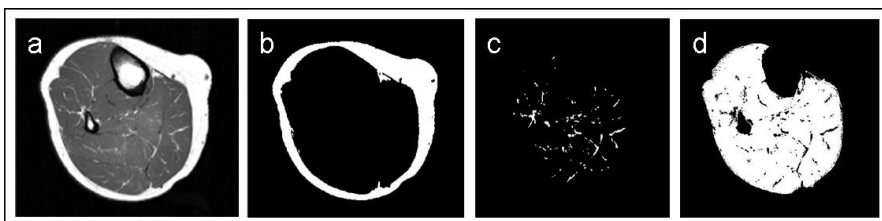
(a) original T1-weighted image and principle of postprocessing for quantification of subcutaneous adipose tissue (SCAT, b), intermuscular fat (IMF, c) and muscle mass (d) from lower leg. Fatty bone marrow of tibia and fibula is excluded.
